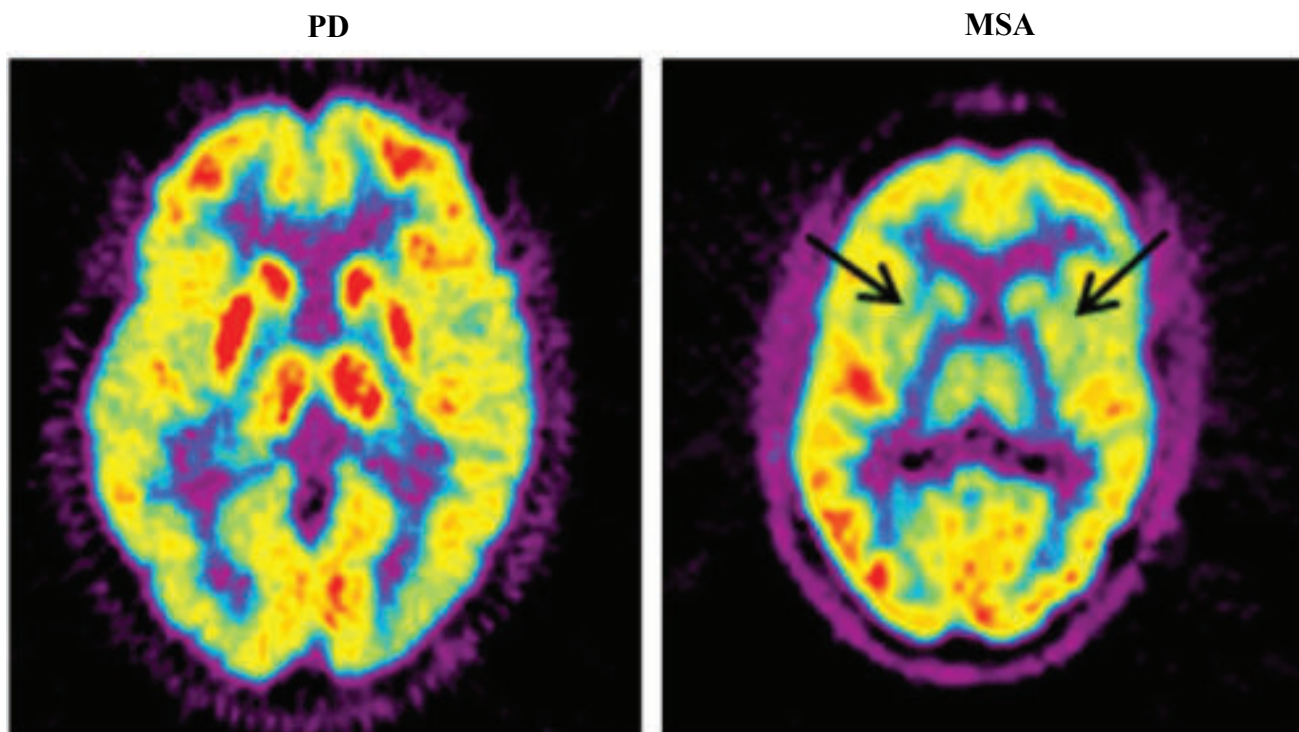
F-18-FDG PET in Parkinson's disease (PD) & Multiple-system atrophy(MSA). 18 F-FDG PET images of PD and multiplesystem atrophy patient. Multiple-system atrophy patient shows significant striatal reduction of glucose metabolism. MSA multiple-system atrophy.
